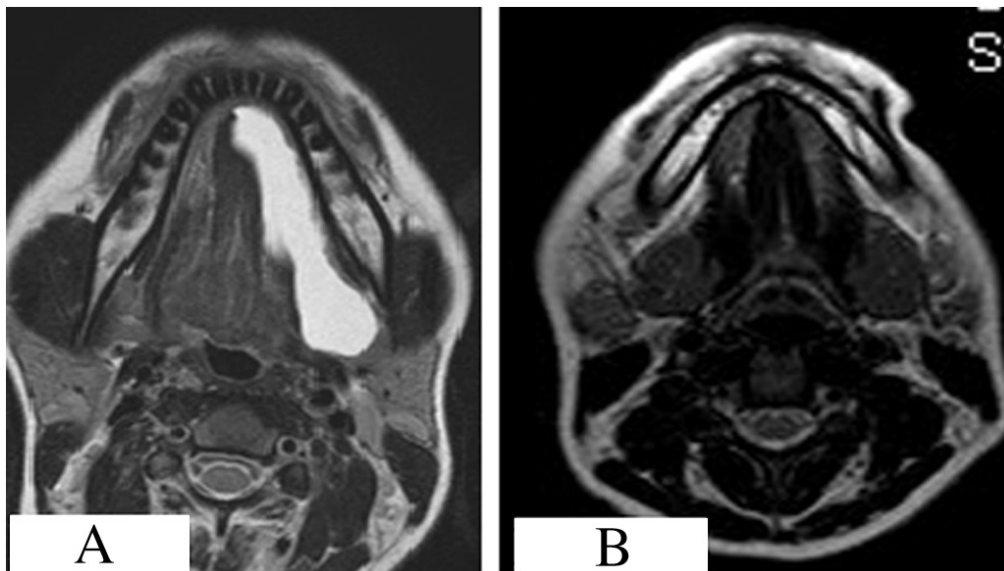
A. Same patient as in Fig. 1A. Pre-operative MRI investigation (axial view) of the plunging ranula.
